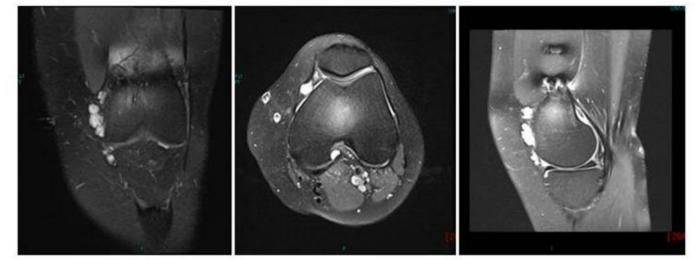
Pre-operative coronal, axial and sagittal knee MRI scans with Gadolinium contrast demonstrating several high signal intensity nodular densities in the medial aspect of the joint consistent with the appearance of a haemangioma
